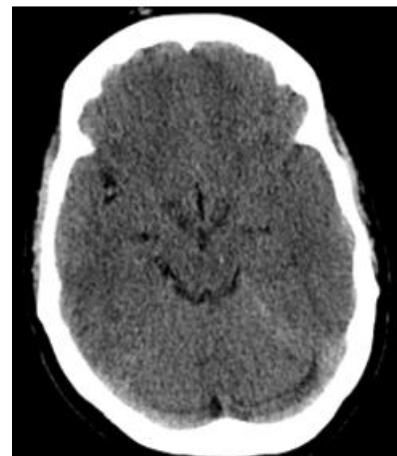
Plain CT Brain on 14/04/2026 (3 days after accident)– Complete resolution of subarachnoid haemorrhage
